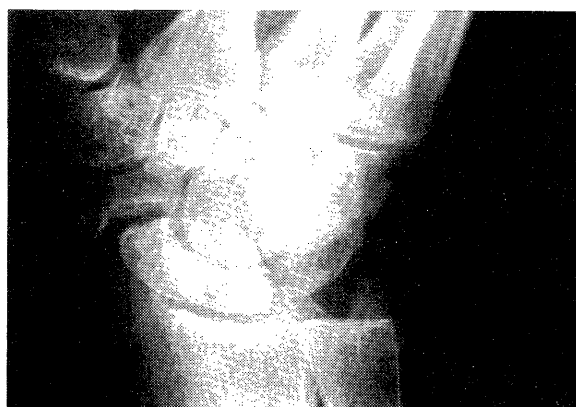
a ; Radiograph showing the established pseudoarthrosis of the scaphoid.
